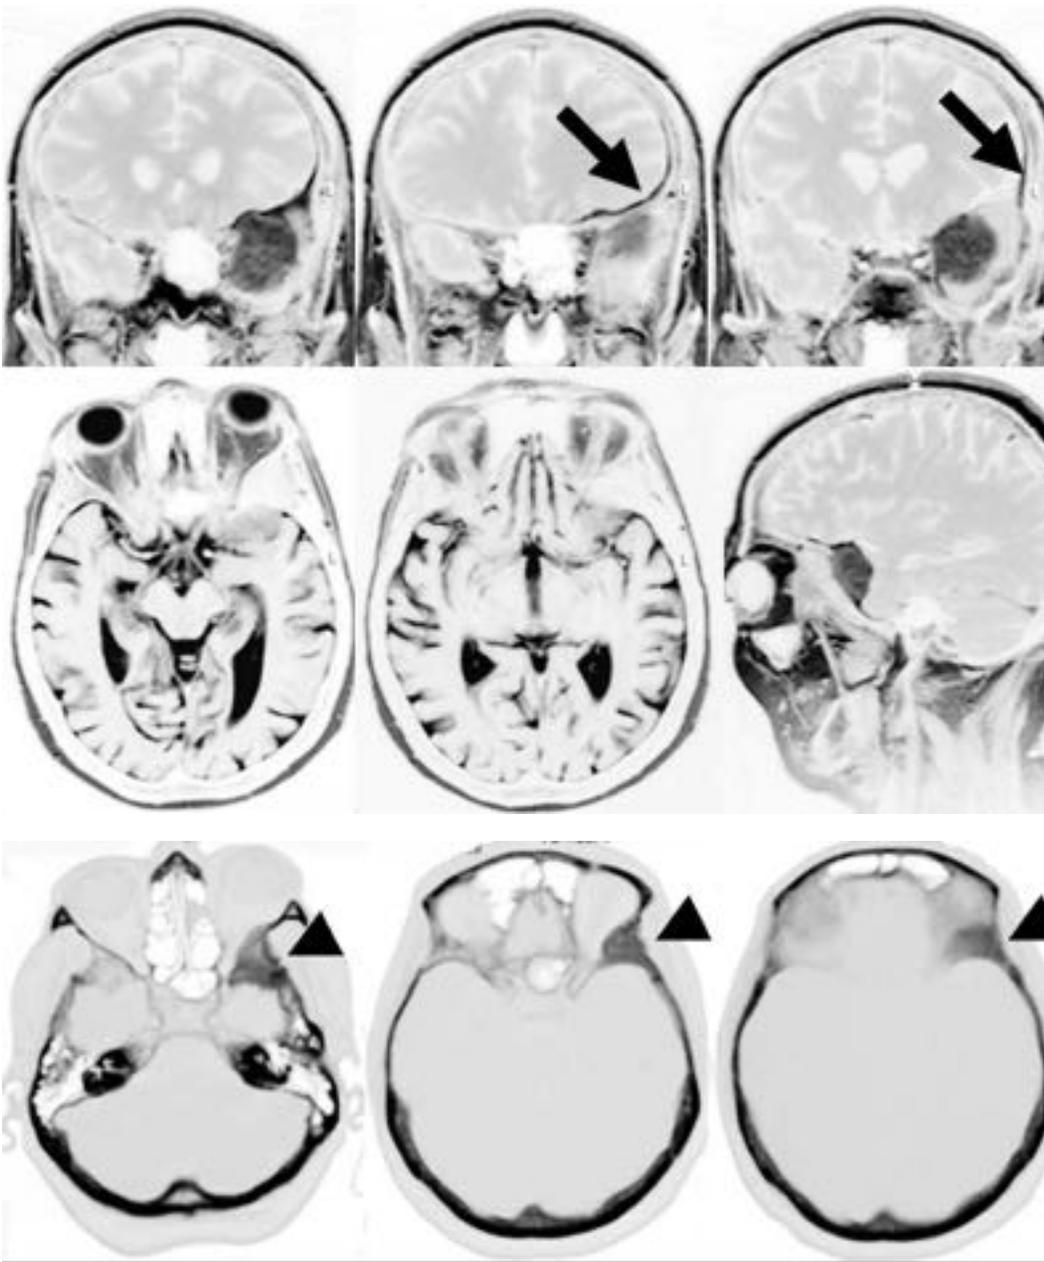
Another small middle sphenoid ridge meningioma (coronal and sagittal T1-weighted contrast-enhanced and axial T2-weighted images; compare Fig. 23.2). (A) In contrast to the tumor shown in Fig. 23.2, there is more widespread dural growth (*arrow*). (B) A computed tomographic scan shows tumorous infiltration of the sphenoid bone (*arrowheads*). Thickening of the lateral orbital wall has already resulted in mild exophthalmos. The bony and dural involvement render this lesion more challenging than the case presented in Fig. 23.2. One could argue that this tumor should be classified more precisely as a sphenoorbital meningioma (compare Fig. 23.7). Copyright M. Simon and J. Schramm, reproduced with permission.
